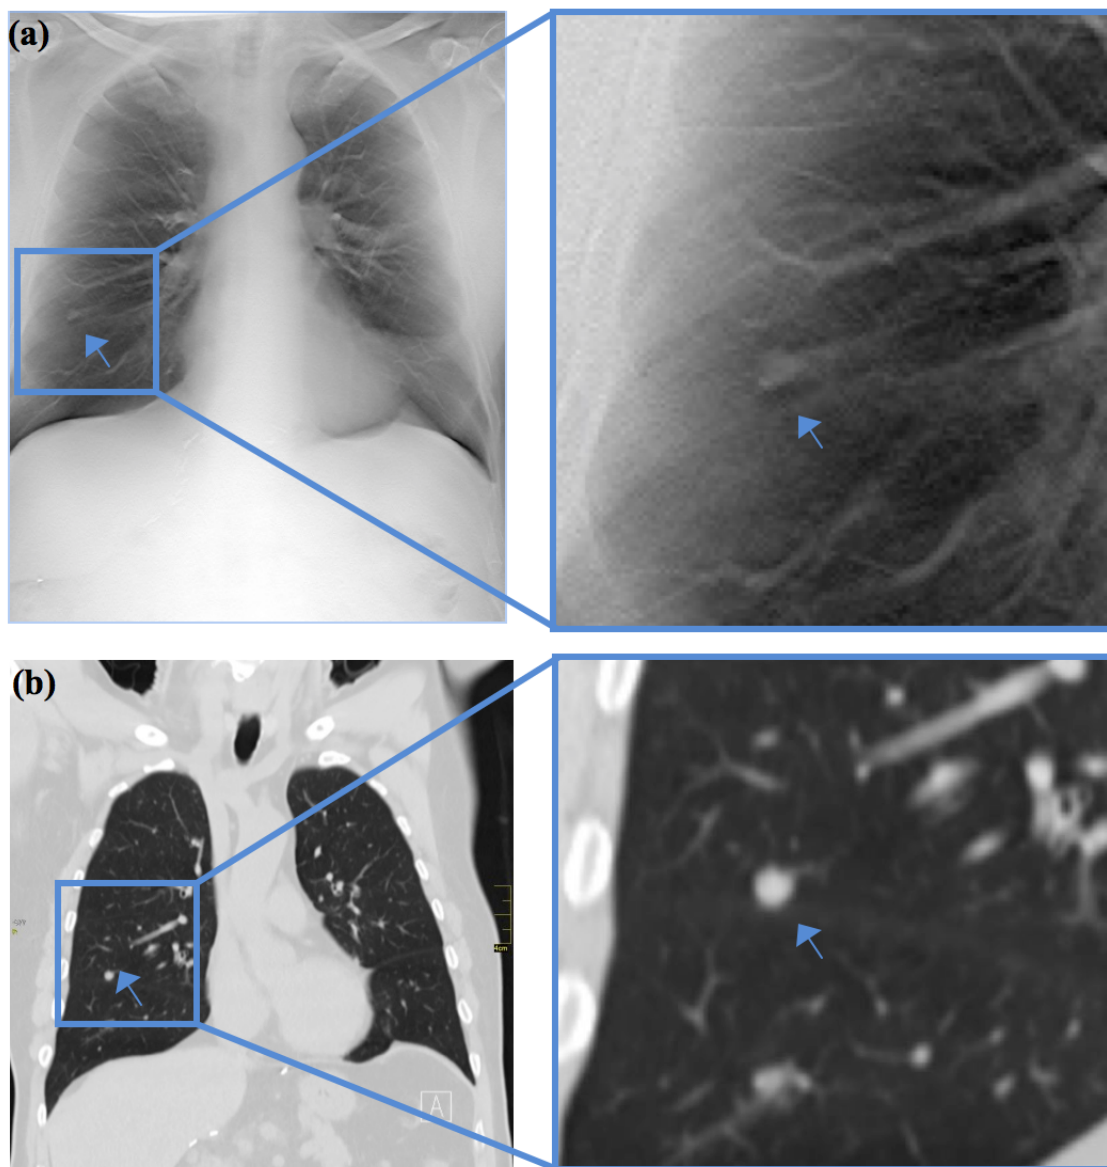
Images of a lung nodule study patient. (a) a slice from the tomosynthesis. The arrow is pointing to a small lung nodule about 5.4mm in diameter (b) the same nodule shown in the CT scan.
